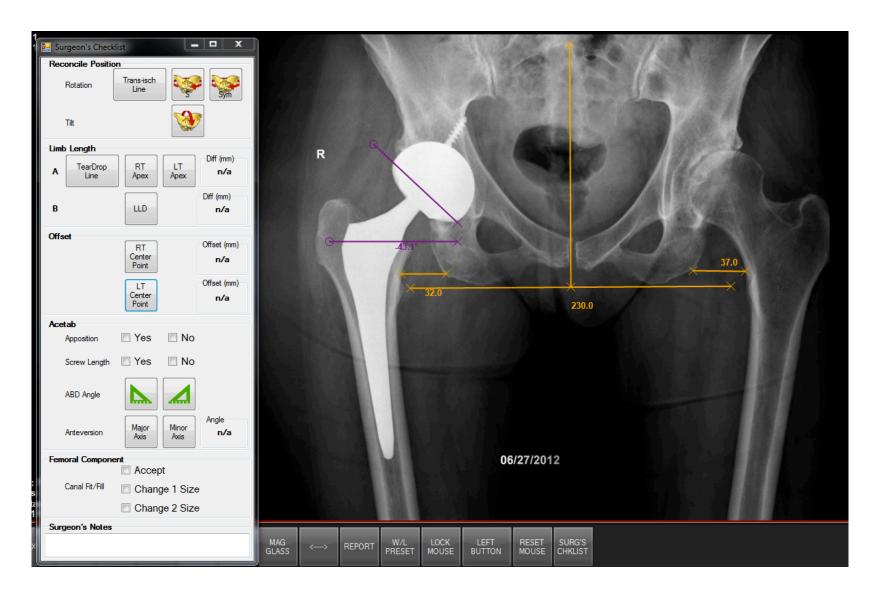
Standard postoperative radiograph surgeon's checklist and measured parameters
